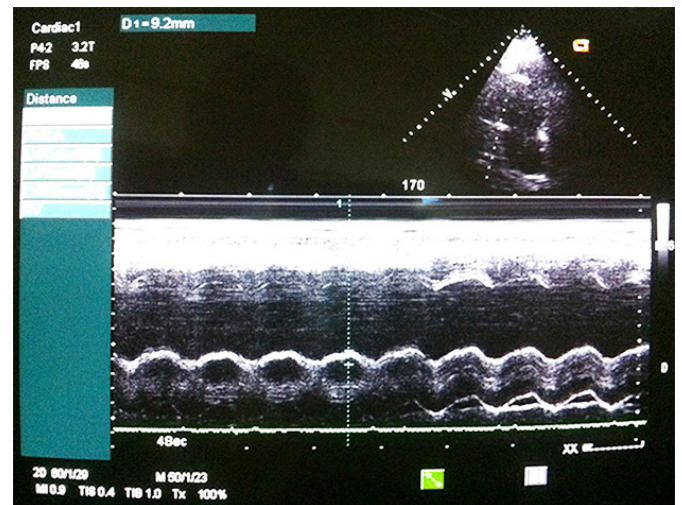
Right ventricular enlargement in transthoracic echocardiography parasternal long axis view.
